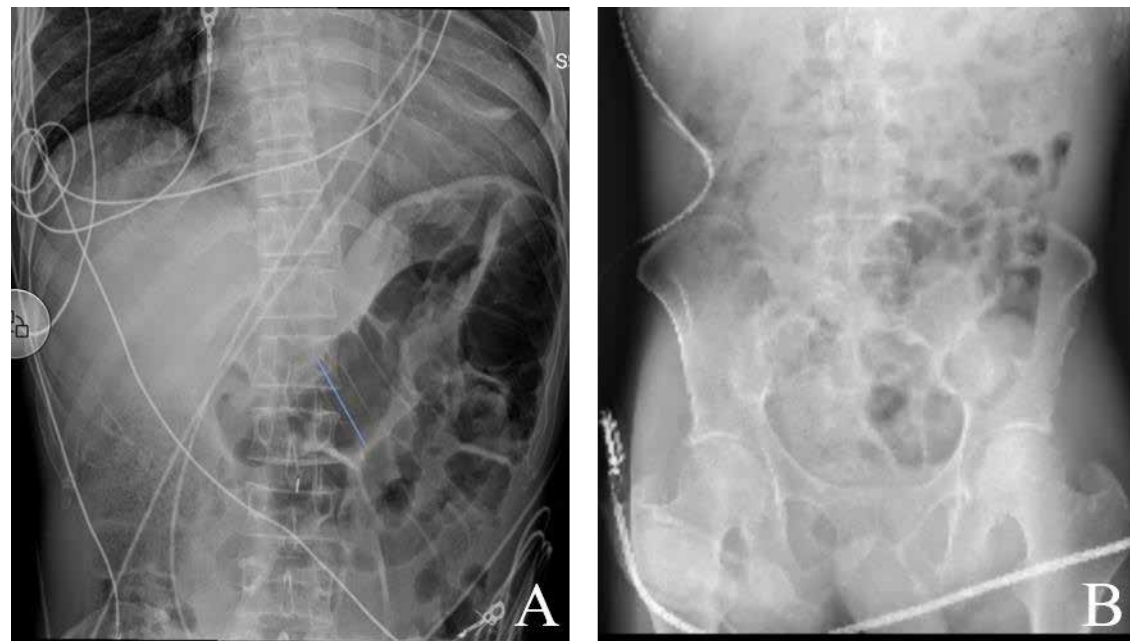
Case 2 Abdominal X-rays A) X-ray taken on the morning of the Impella 5.5 insertion B) X-ray taken on the morning of the left ventricular assist device placement.
